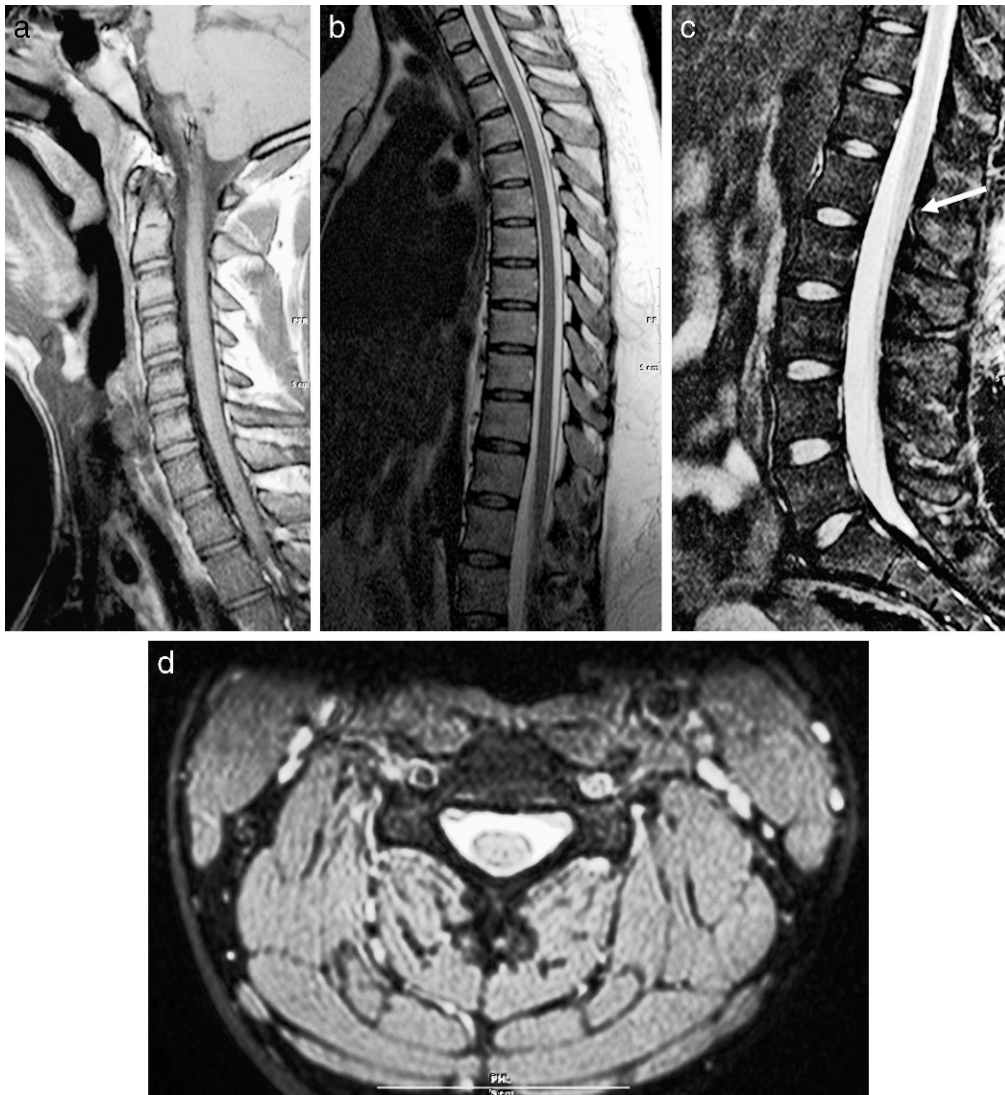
Normal anatomy. (a) Sagittal T1-weighted image of the cervical spine. (b) Sagittal T2-weighted image of the cervical spine. (c) Sagittal T2-weighted image of the lumbar spine. Notice the normal termination of the spinal cord at the thoracolumbar junction (arrow). (d) Axial T2-weighted image of the cervical spine.
